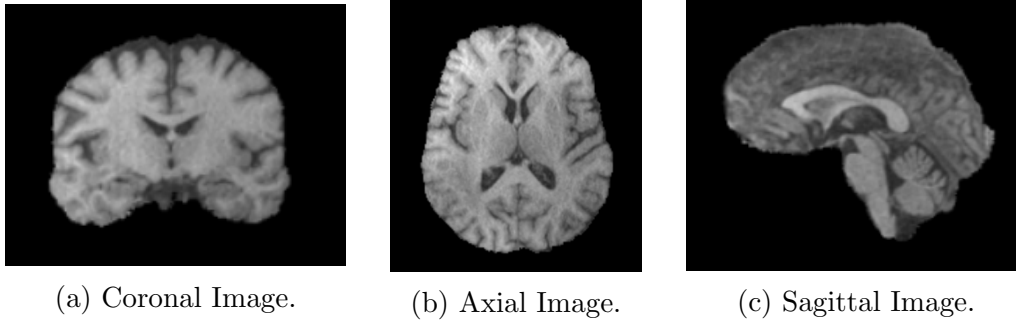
Coronal, Axial, Sagittal 3D MRI images of a brain volume.
